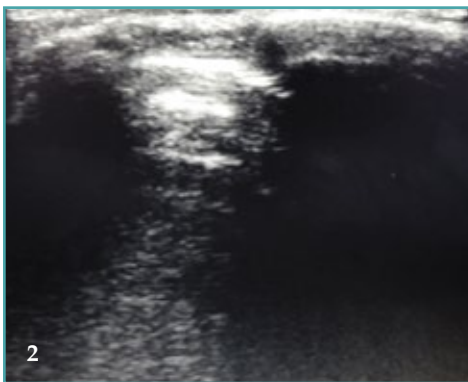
Ultrasonographic view of the CTM using the longitudinal technique (Photo by Lothar Schwarte).*
